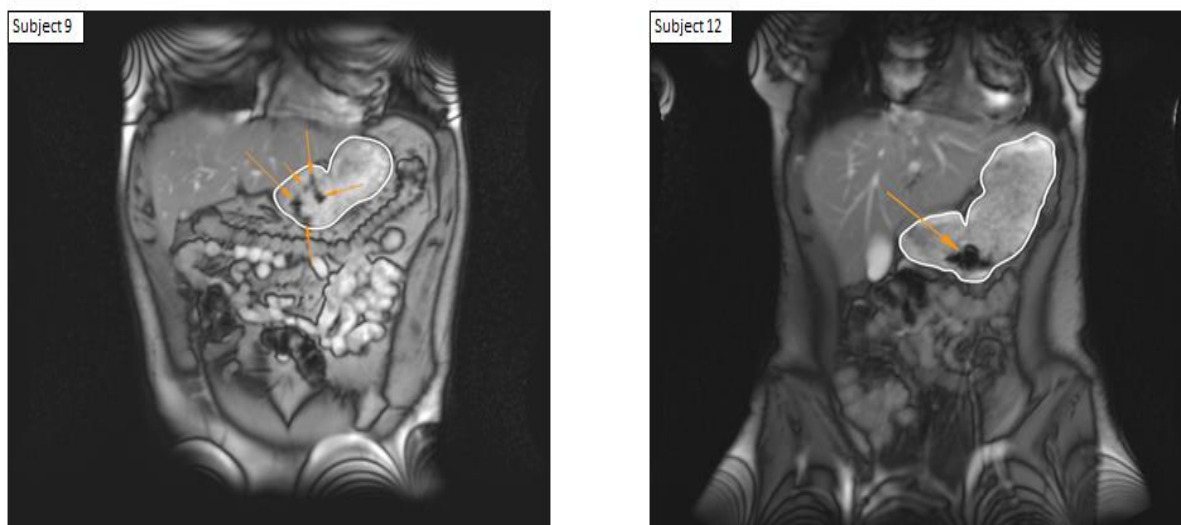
Representative MRI pictures showing the location and disintegration behavior of matrix tablets taken 4 h after administration of tablets containing 100 mg of caffeine to subjects 30 min after FDA meal with 240 mL of tap water.
